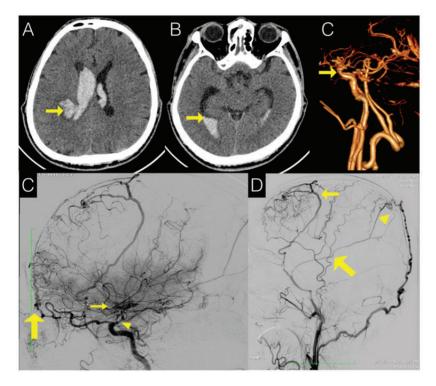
(A) Axial non-contrast cranial computed tomography (CT) scan. 3 cc bleed (arrow) in the right parietal lobe with intraventricular (IV) extension. (B) Axial non-contrast CT. Obstructive hydrocephalus and the IV extension (arrow) of the bleed in the temporal horns of the lateral ventricles. (C) Cranial CT angiography. Cutoff (arrow) on both internal carotid arteries (ICA). (D) Four vessel angiography (4VA) selective right ICA injection shows: near total occlusion of the distal part of the communicating segment of the ICA (arrowhead), Moyamoya vessels characterized by the net-like tangle of vessels over the ICA occlusion (small arrow), prominent ophthalmic artery (big arrow) consistent with extracranial-intracranial anastomosis. (D) 4VA selective right external carotid artery injection showing collateral supply to the territories of the anterior and middle cerebral arteries: occipital artery (arrow head), middle meningeal artery (small arrow), and superficial temporal artery (big arrow).
